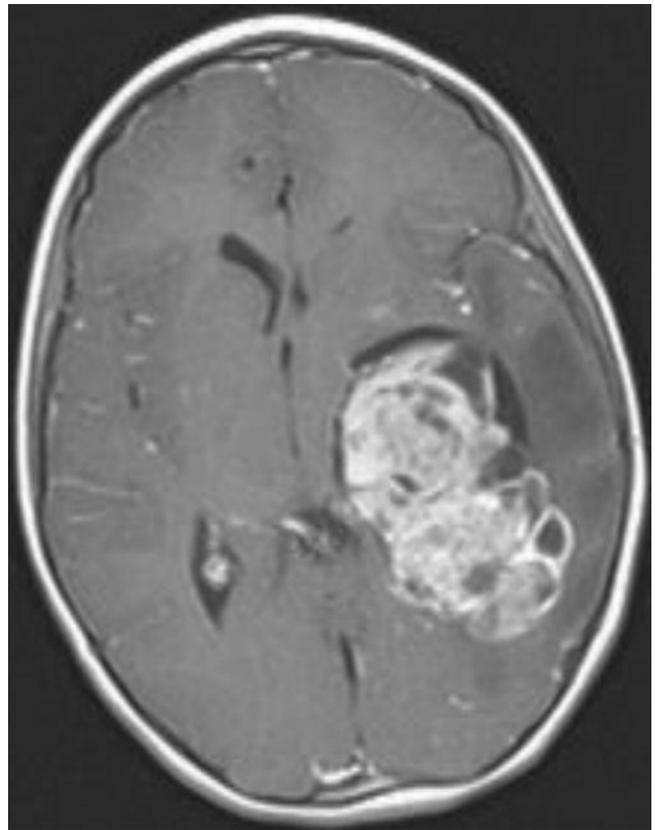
Preoperative axial postcontrast T1-weighted MR image showing a large, demarcated solid-cystic mass (soap-bubble appearance) in the left temporooccipital ventricular horn.
